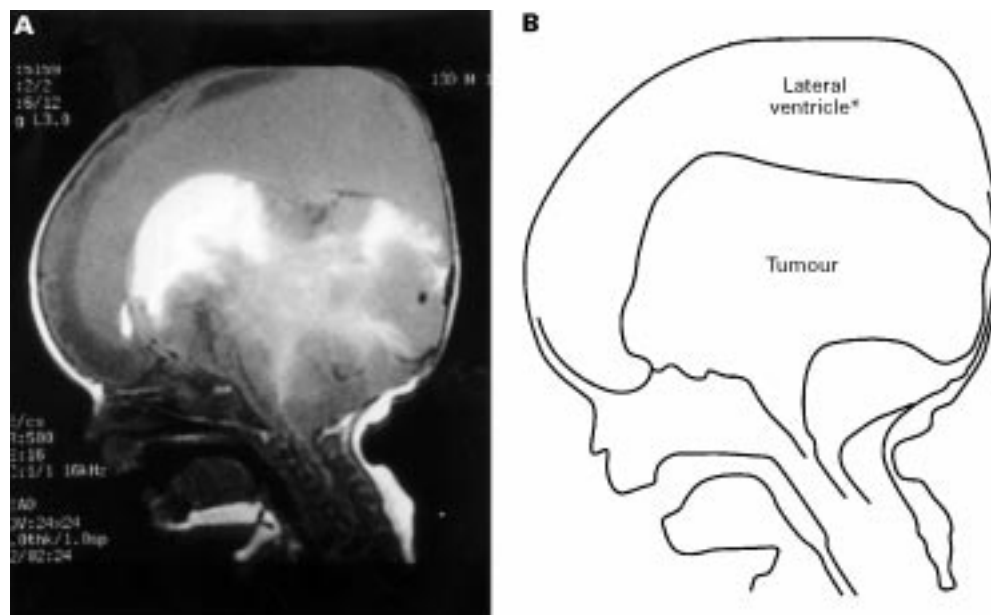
T1 weighted MRI scan (sagittal section): CSF looks grey due to high protein content.
